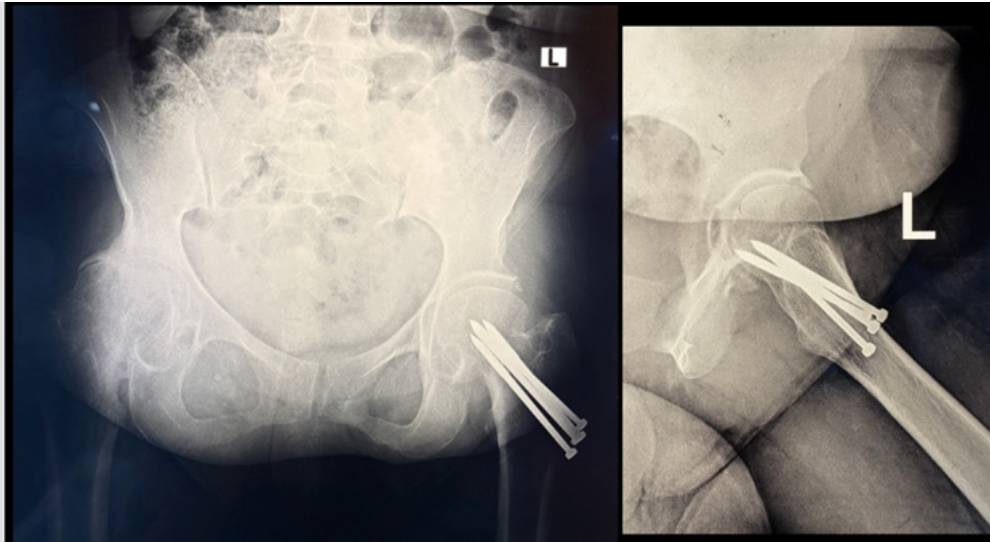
Pre-Operative Pelvis AP and Left Hip Lateral Radiographs: Right Hip with Severe Osteoarthritis and Left Hip with 4 Knowles Pins in-Situ
